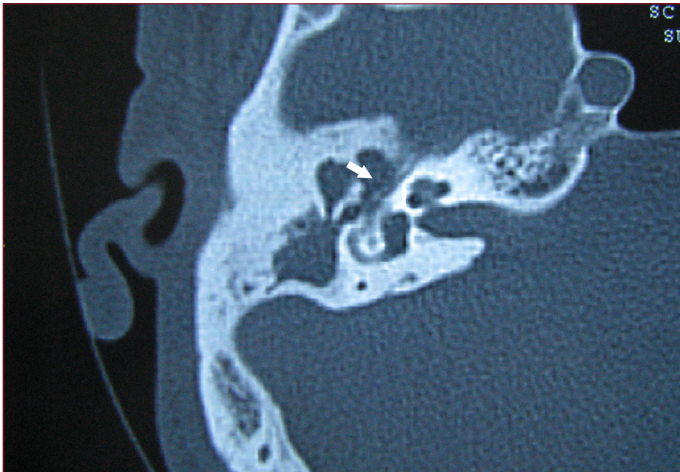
CT image. Dehiscence of the facial nerve tympanic segment, white arrow
